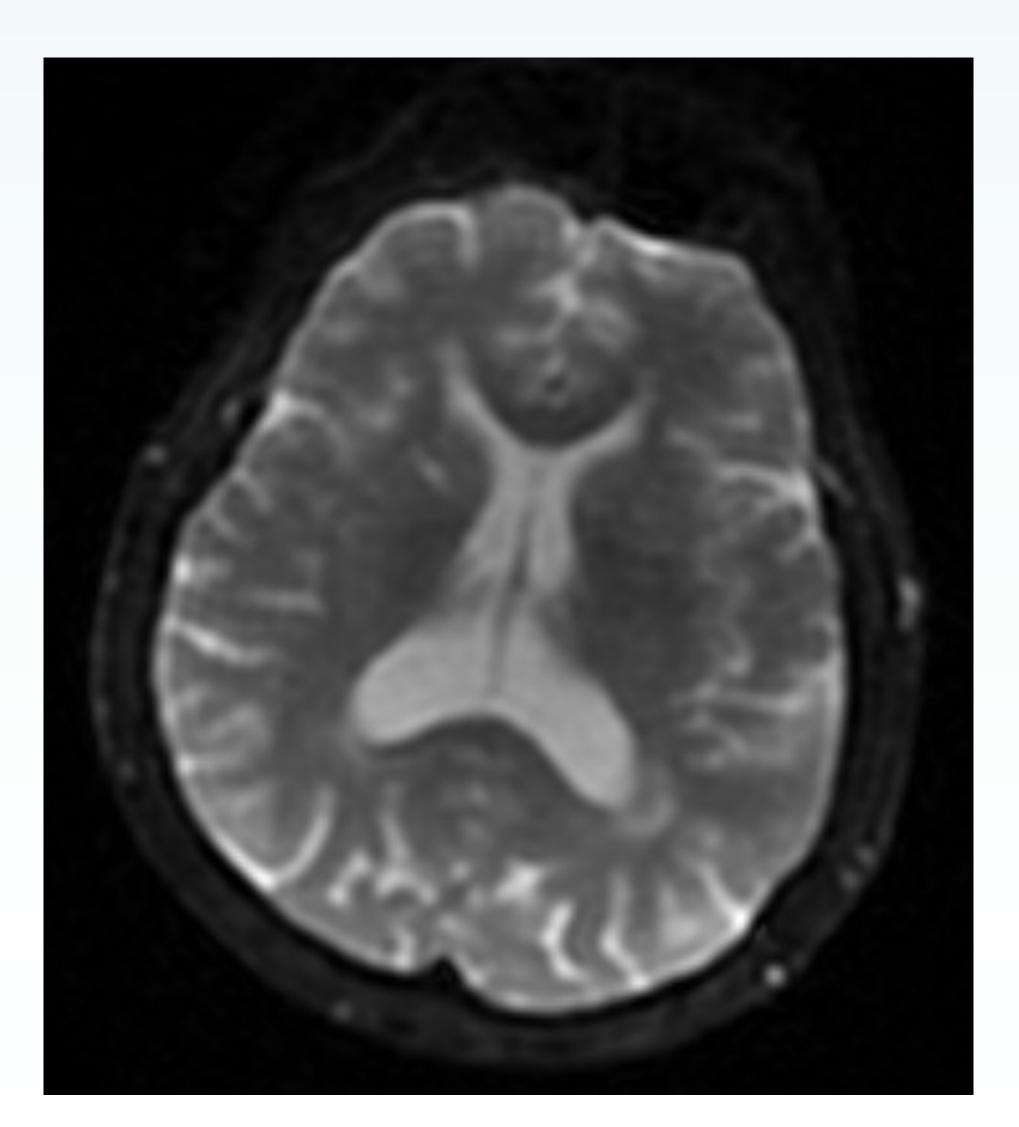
MRI of the Brain w/o contrast – no evidence of acute ischemia. Noted severe motion artifact.
